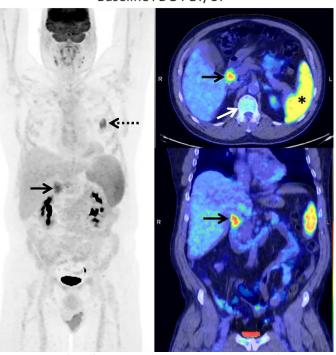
Baseline ¹⁸F-FDG PET/CT images performed for lung cancer staging show expected FDG uptake in lung mass (dotted black arrow on whole body maximum intensity projection image) and incidental focal FDG uptake in proximal duodenum (SUV $_{max}$ =7.3), splenomegaly with increased splenic uptake (SUV $_{max}$ =5.8) and diffuse bone marrow uptake (SUV $_{max}$ =3.1) relative to liver (SUV $_{max}$ =2.8). The spleen measured 16.5 cm in craniocaudal dimension
